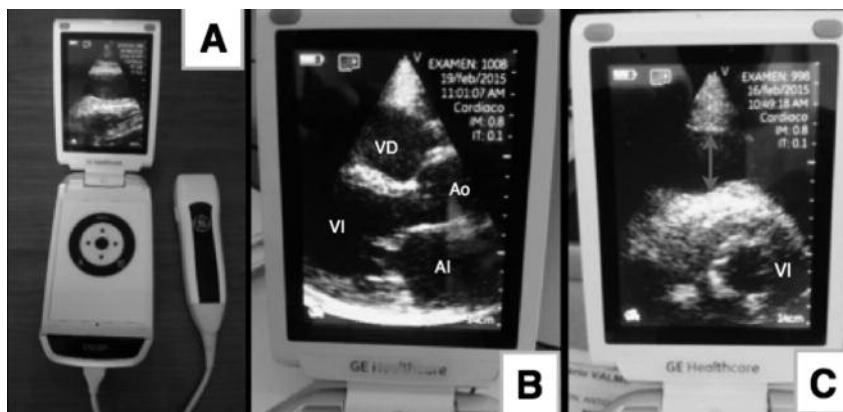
A) GE Vscan hand-held ultrasound machine. B) Long parasternal plane showing dilated left ventricle (LV) and left atrium (LA) with reduced thickness of the interventricular septum; right ventricle (RV) and aorta (Ao). C) Short parasternal plane in which severe pericardial effusion is shown (arrow).
